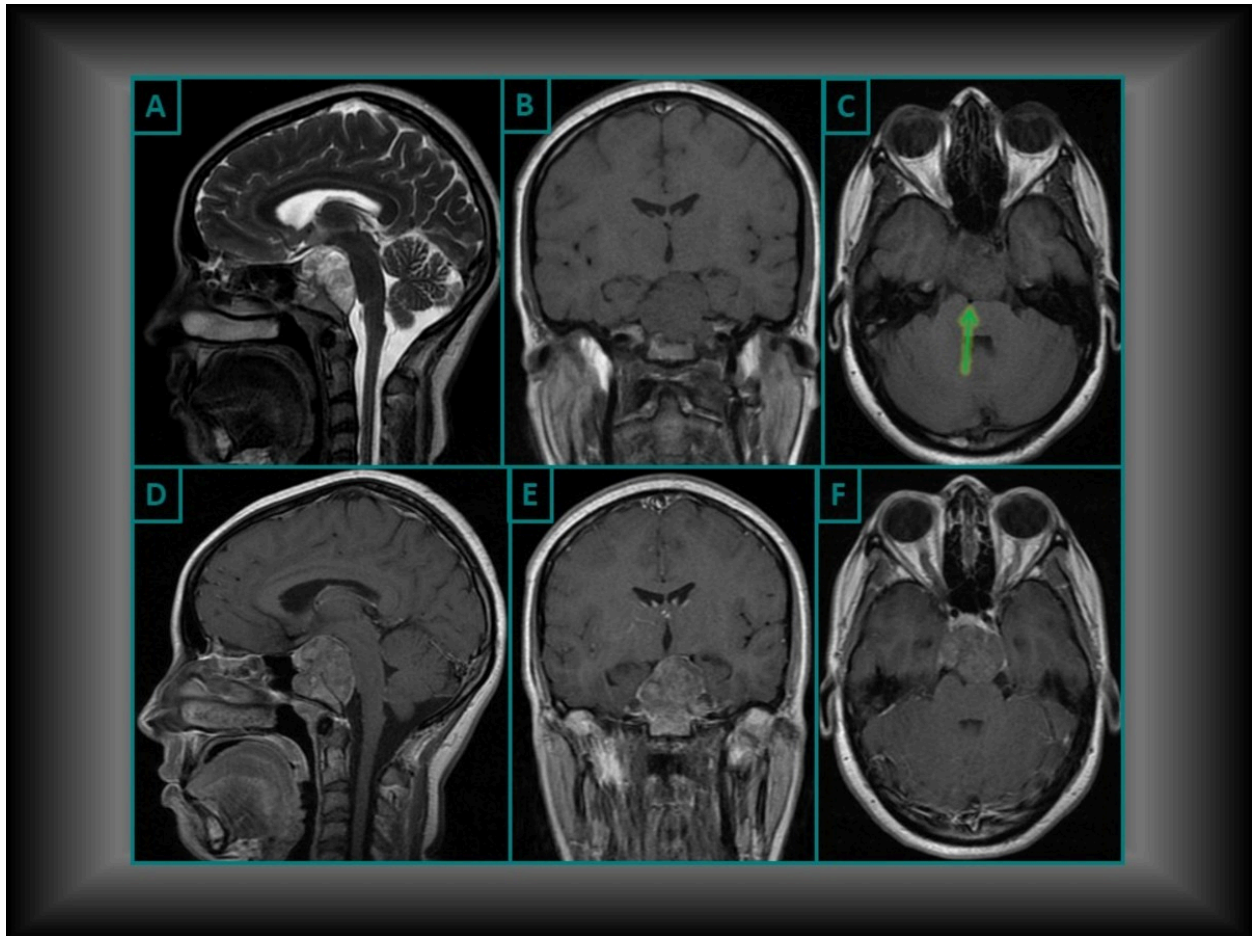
CHORDOMA Sagittal T2-W (A), Coronal T1-W (B), Axial T1-W (C), Sagittal post-contrast T1-W (D), coronal post-contrast T1-W (E) and Axial post-contrast T1-W (F). Images showing the chordoma involving the clivus. The lesion is heterogeneous and hyperintense in T2-weighted sequences, slightly hypointense in T1, and with heterogeneous enhancement. The mass occupies the prepontine cistern with compression on the anterior margin of the protuberance and displacement of the basilar artery (Green arrow).
